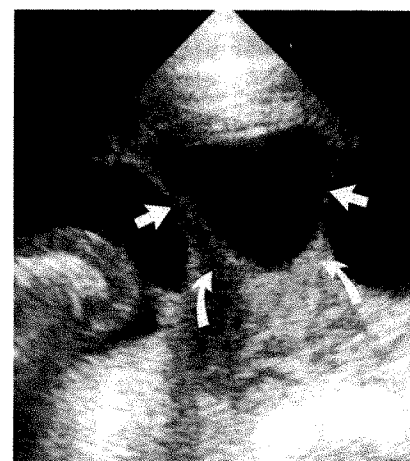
Sonogram shows two separate shelves (straight arrows) in body of uterus in this 21-week pregnancy. Note thickening of base (curved arrows) of shelves.
